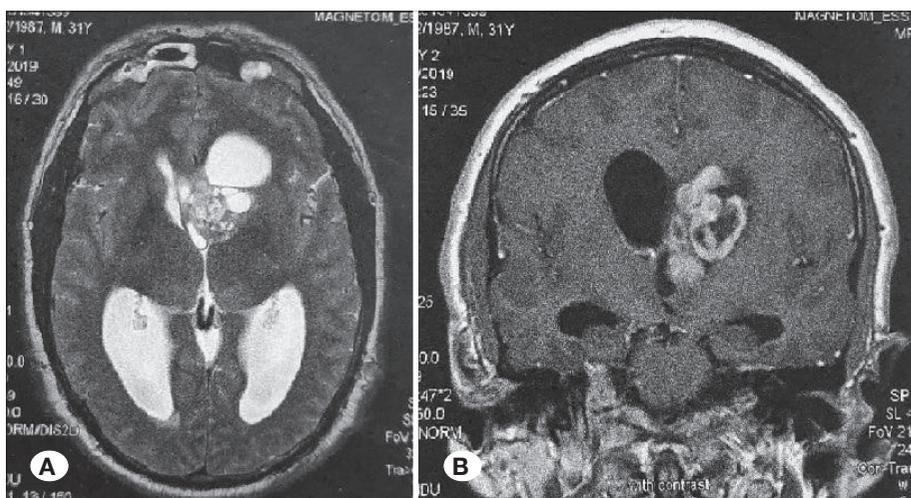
Case 1 - intraventricular ganglioglioma. Preoperative axial T2W (A) and coronal T1W contrast enhanced (B) MRI scans: left LV tumor, extending into V3, ventriculomegaly.
